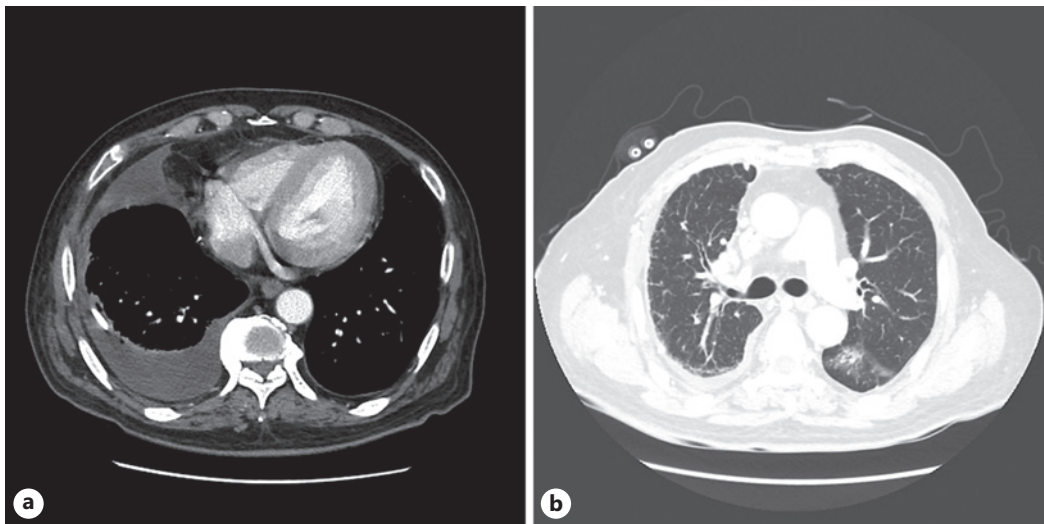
Chest CT images from November 3rd, 2022. a Right pleural effusion; pigtail catheter inserted. b Irregular consolidation and ground-glass opacities in the superior segment of the left lower lobe.
